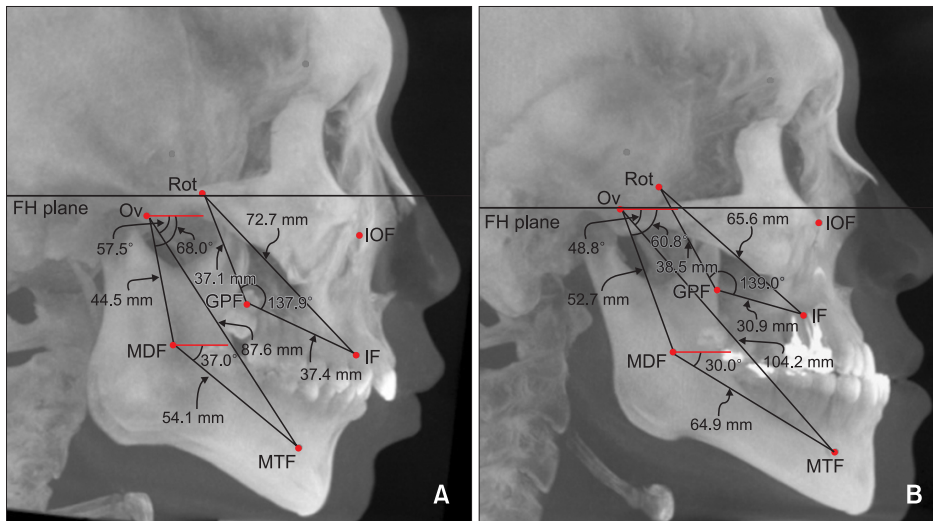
The locations of landmarks and measurements were visualized in the lateral maximum projection image of cone-beam computed tomography. Values of linear and angular parameters as measured in a 22-year-old male patient with skeletal Class II malocclusion (A), and a 23-year-old male patient with skeletal Class III malocclusion (B). FH, Frankfort horizontal plane. See Table 2 for definition of each landmark.
